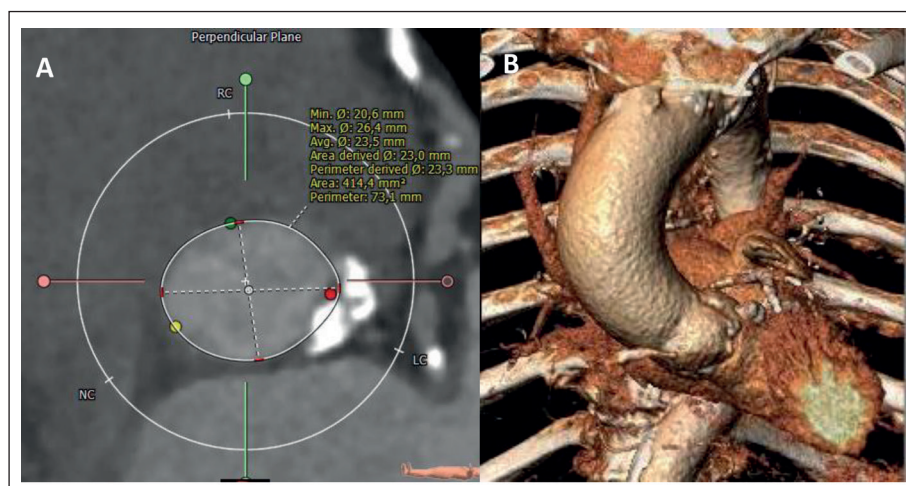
Pre-interventional multislice computed tomography (MSCT) displaying (A) the measurements of the aortic annulus and (B) the horizontal configuration of the aortic root and ascending aorta.
